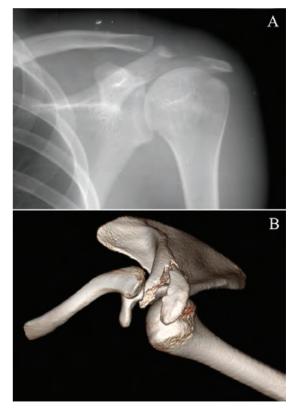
Pre-operative imaging of the left shoulder including a A) plain radiograph and B) 3D CT reconstruction demonstrating a displaced fracture of the posterolateral angle of the acromion.
